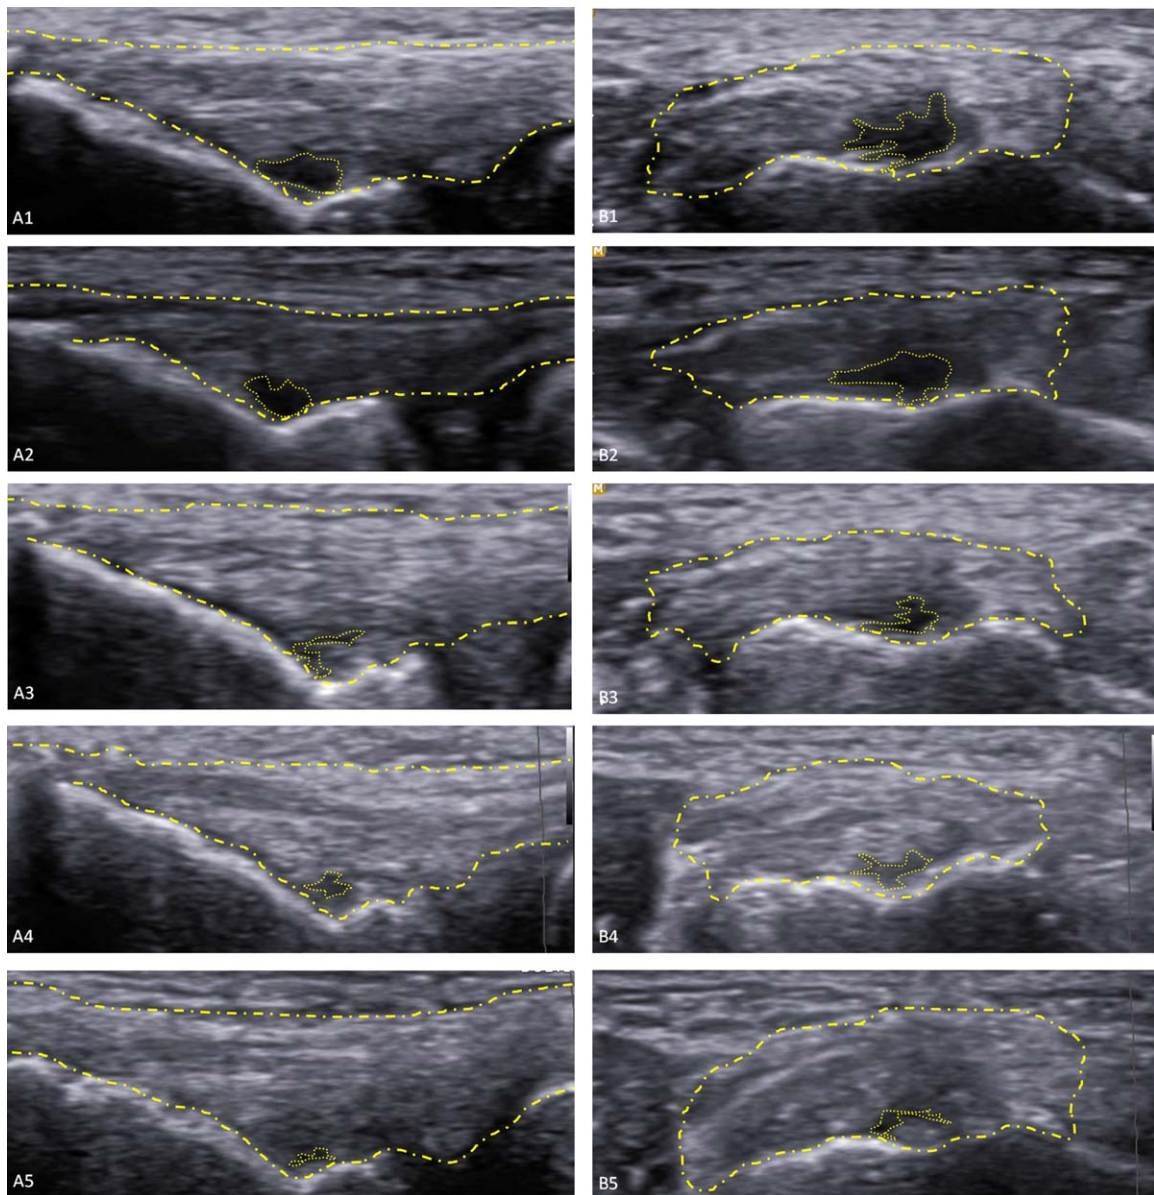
Changes of Defect. Typical serial ultrasonographic images of the largest hypoechoic lesion of longitudinal (left column) and transverse (right column) axes in a subject (A1/B1: day 0, A2/B2: 6 weeks, A3/B3: 12 weeks, A4/B4: 26 weeks, and A5/B5: 52 weeks after injection). Yellow dash-dot lines and dotted polygons represent the common extensor origin tendon and the defect of the tendon, respectively.
